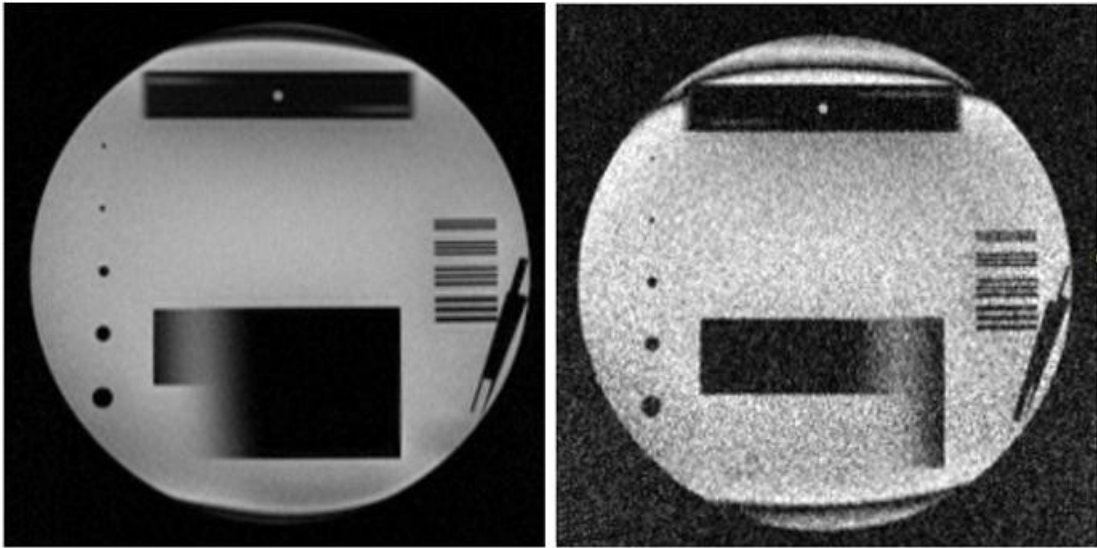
Comparison of MR images taken when electronic components inside the MRI scanner room are not powered (l) and powered (r).
